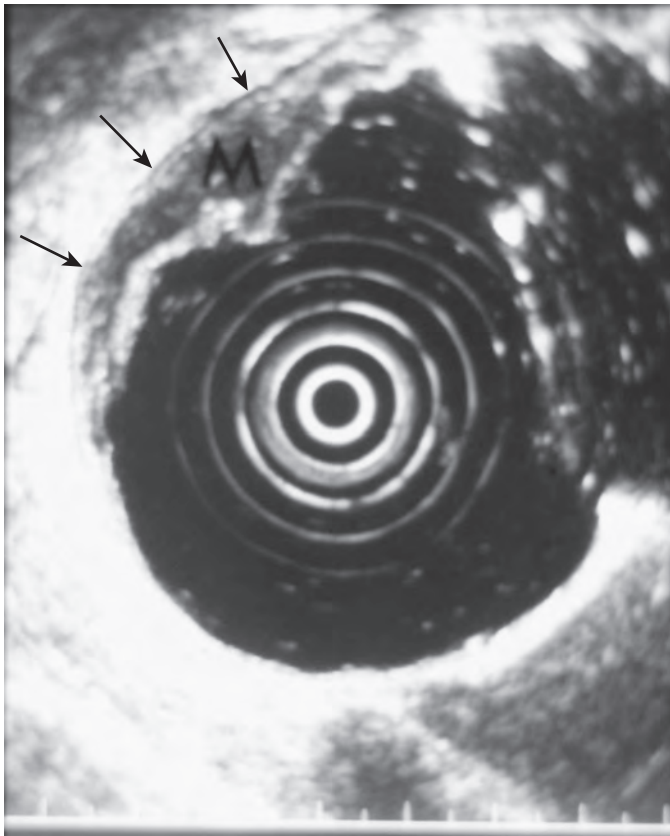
Endoscopic ultrasound of esophageal cancer. Endoscopic ultrasound shows a hypoechoic mass (M) causing focal widening of the esophageal wall. The thin black line peripherally (arrows) indicates that the tumor has not yet invaded the serosal fat.
